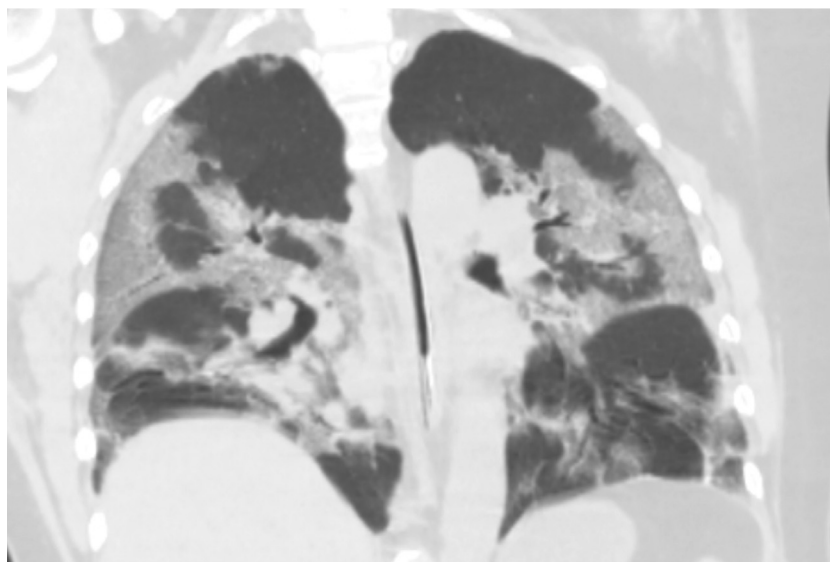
Chest computed tomography at 21 days after COVID-19 onset (day 21) showing multiple lung frosted shadows.
